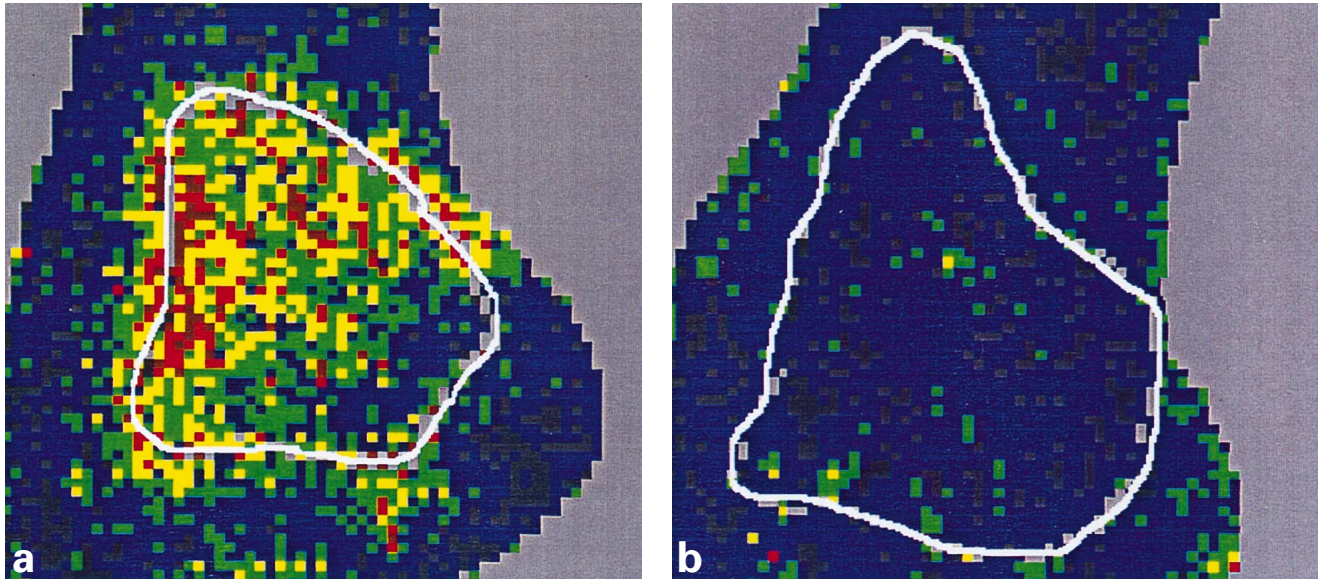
(a) Preoperative laser Doppler scanning picture. The palpable lipodermatosclerotic area is outlined by grey markings. (b) Postoperative laser Doppler scanning picture. The blood flow in the transplanted area is normalized.
